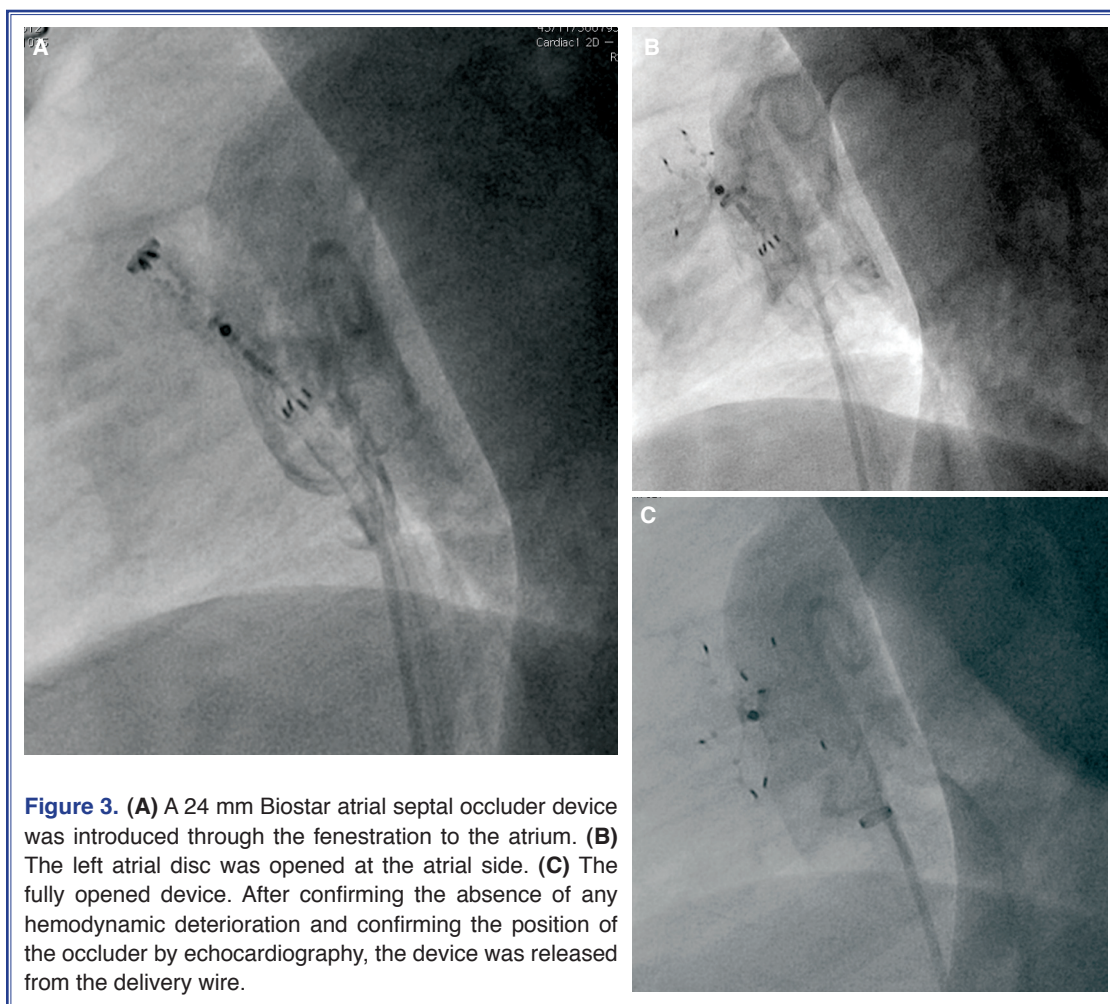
(A) A 24 mm Biostar atrial septal occluder device was introduced through the fenestration to the atrium. (B) The left atrial disc was opened at the atrial side. (C) The fully opened device. After confirming the absence of any hemodynamic deterioration and confirming the position of the occluder by echocardiography, the device was released from the delivery wire.
